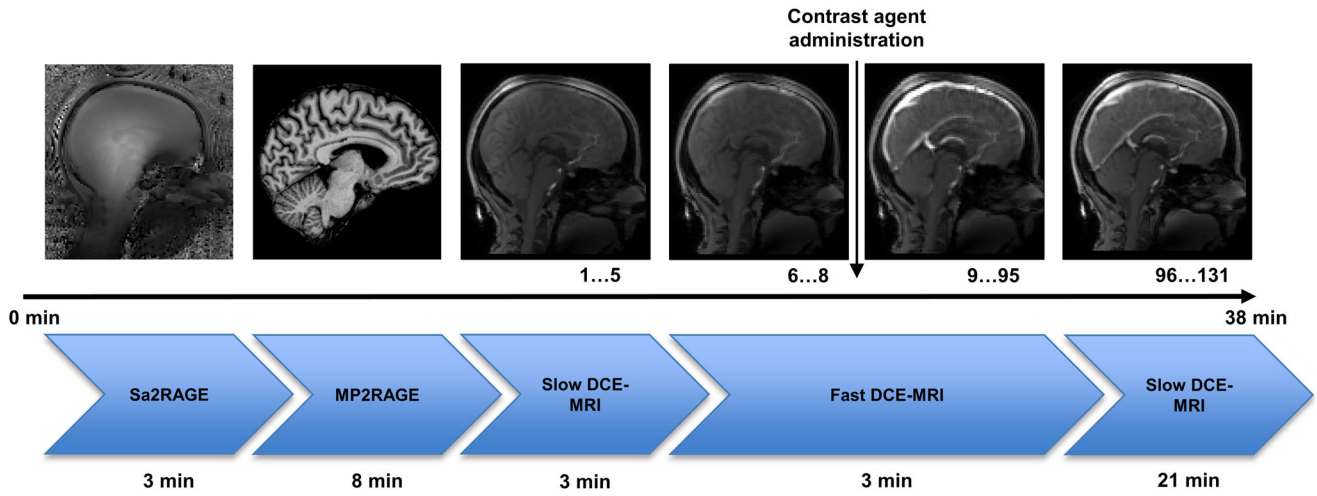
Timeline of the imaging protocol with example images and acquisition time. The administration of the contrast agent is denoted with the vertical arrow. The number of dynamic phases is stated under the MR images. Abbreviations: DCE-MRI, dynamic contrast-enhanced MRI; Echoes; MP2RAGE, Magnetization-Prepared 2 Rapid Acquisition Gradient Echo; min, minutes; Sa2RAGE, Saturation-prepared with 2 Rapid Gradient
